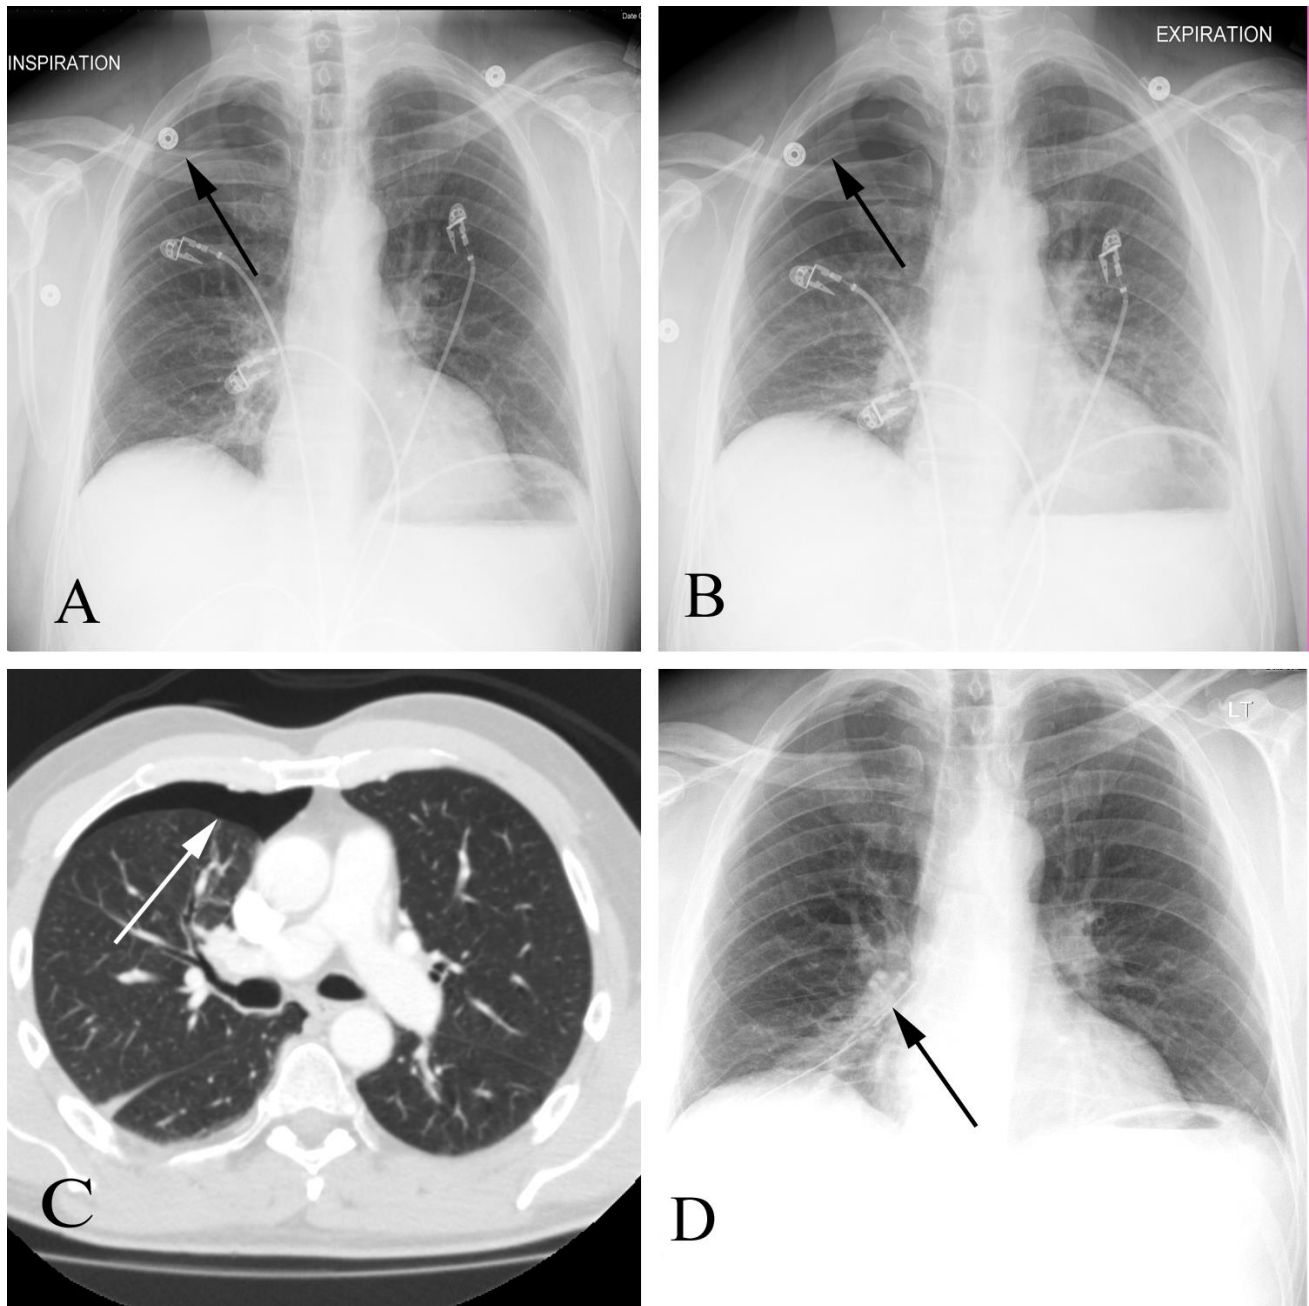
Pneumothorax in a 53 year old man with chest pain and dyspnea following trauma. A. PA inspiration chest x-ray shows a subtle pleural line (arrow) on the right side. B. PA expiration chest crowds the pulmonary vessels. C. On the CT study, the pneumothorax is much more conspicuous (arrow). D. Chest x-ray shows resolution of the pneumothorax following chest tube placement (arrow).
